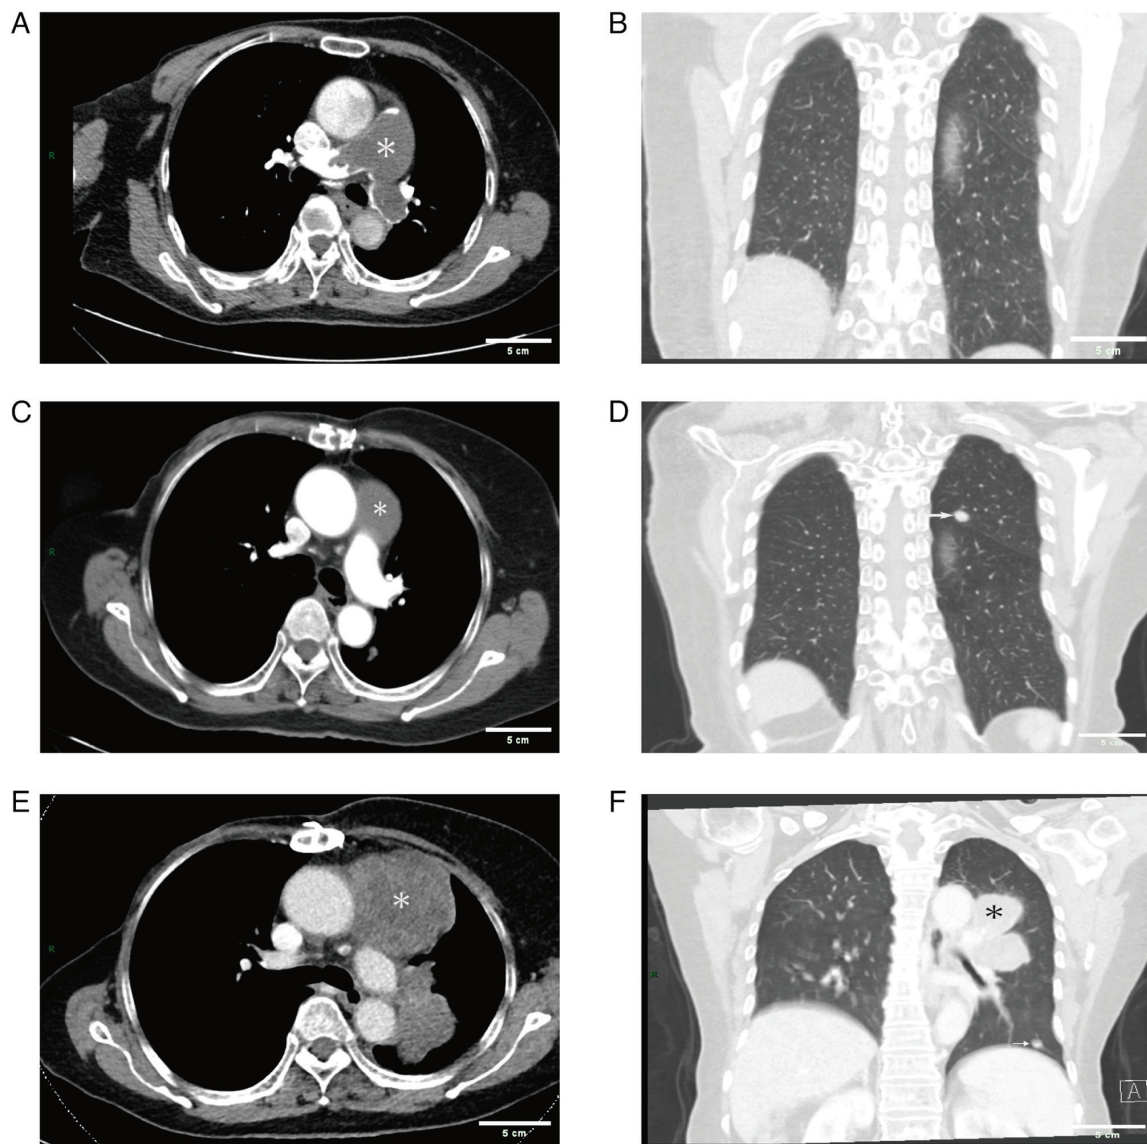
Chest imaging results. (A) Preoperative CTPA showed dilation of the pulmonary trunk (~37 mm), filling defects in the main pulmonary artery, as well as the left and right pulmonary arteries, (B) with no nodules in the lung. (C) Chest-enhanced CT in December 2020 showed a low-density filling defect in the main pulmonary artery and (D) a 10-mm nodule in the upper left lobe of the lung. (E) Repeat chest-enhanced CT in March 2021 showed a significant enlargement of the low-density lesions (~68x67 mm) in the main pulmonary artery, (F) as well as multiple fresh soft-tissue masses in the left lung. Asterisks indicate the location of the lesion. Arrows point to the lung nodule. CTPA, computed tomography pulmonary angiography.
